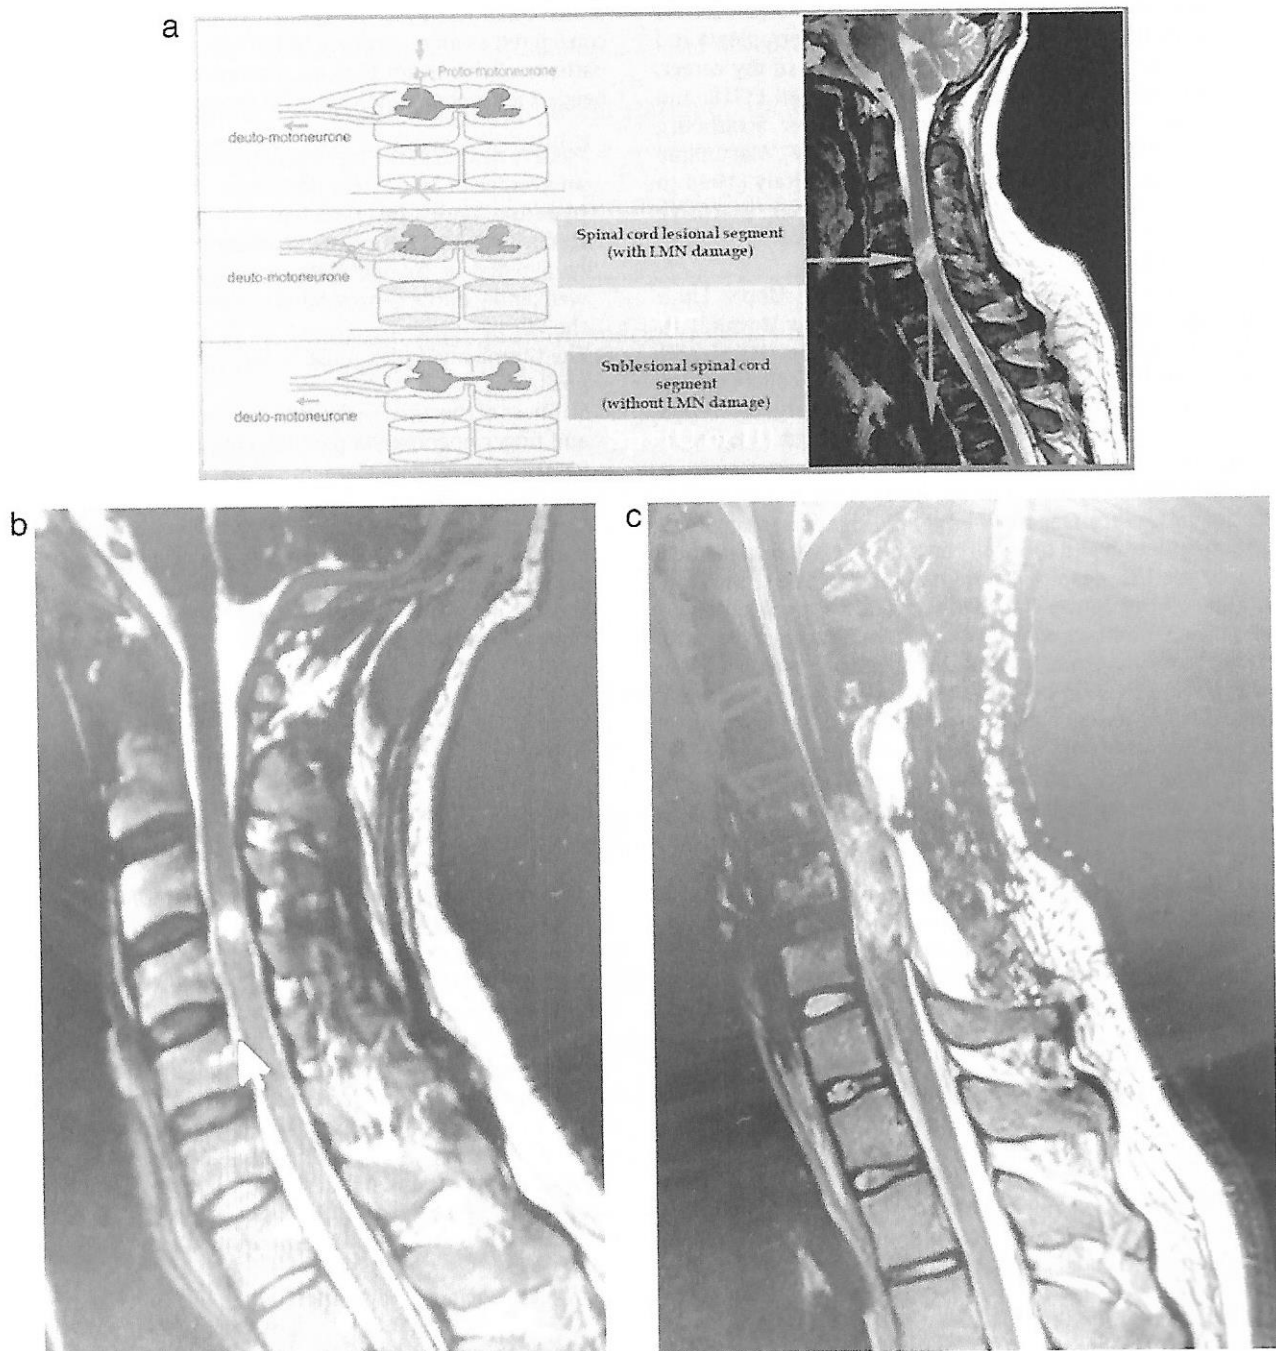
The two tetraplegia spinal cord segments. The lesional segment (LS) and the sub-lesional segment (SLS) (A). MRI: Short lesional segment and extended sub-lesional segment (B). MRI: Spinal cord injury that extends lengthwise (C). LMN: lower motor neurons.
